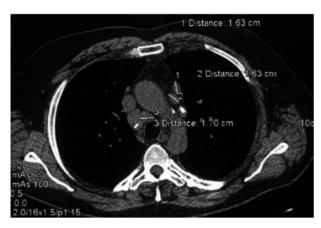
Axial chest computed tomography without contrast media administration showed enlarged hilar and mediastinal lymph nodes. Peribronchovascular and interlobar septa are thick with nodal lesions connected to the pleura, corresponding to the lymphoid type of distribution in parenchymal sarcoidosis. There are signs of fibrosis within the lower lung lobes (not seen in these images).
